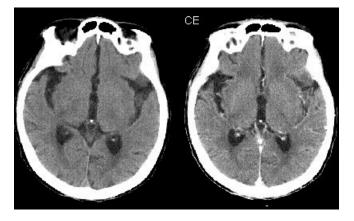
87 year old woman with neoplastic meningitis from gastric cancer. Cranial contrast enhanced CT showed no apparent parenchymal enhancement. Leptomeningeal enhancement was evident in the left frontal and temporal lobes. CE: contrast enhanced.
